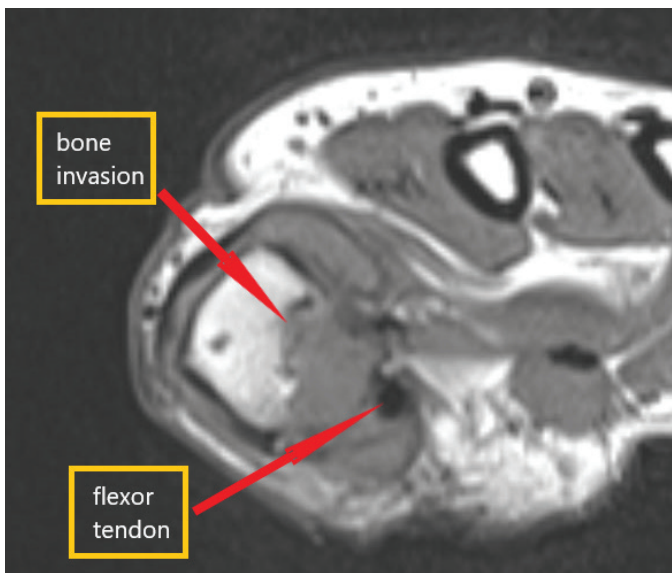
Intraosseous invasion. Magnetic resonance images of the thumb
